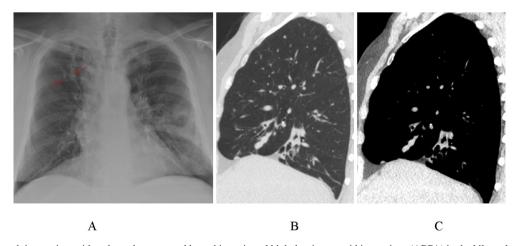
Frontal radiograph in a patient with asthma shows central bronchiectasis and high density mucoid impactions (ABPA) in the bilateral upper lobes (finger-inglove sign) (1A). Computerized tomography in two patients with ABPA shows central bronchiectasis and high density mucoid impactions (ABPA) in right middle lobe (1B, 1C).
